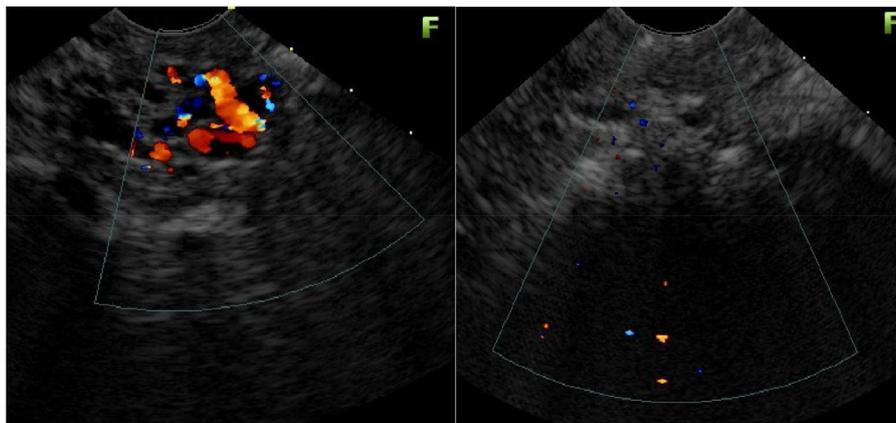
Endoscopic ultrasound with Doppler showing the IGV-1 before and after endoscopic treatment.
